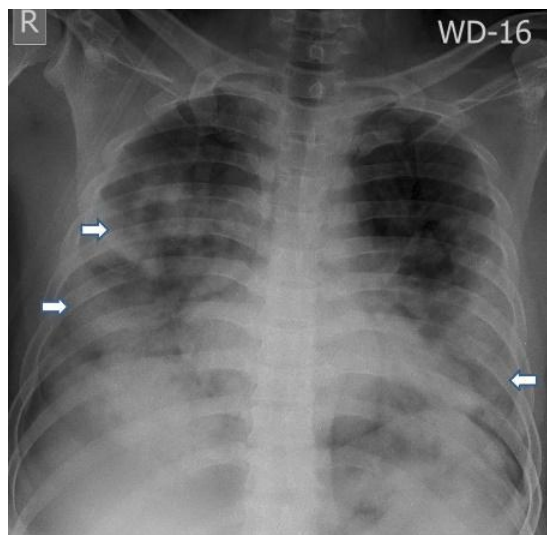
AP chest radiograph reveals multiple ground glass opacities in central and peripheral distribution of both lungs (thick arrows)
